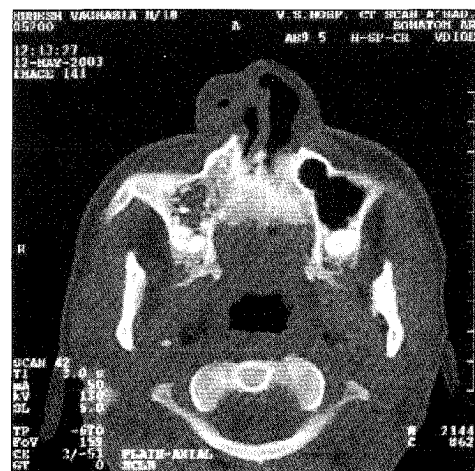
CT Scan: Deviated nasal septum; absent right turbinates; normal orbit, zygomatic, and frontal bones
